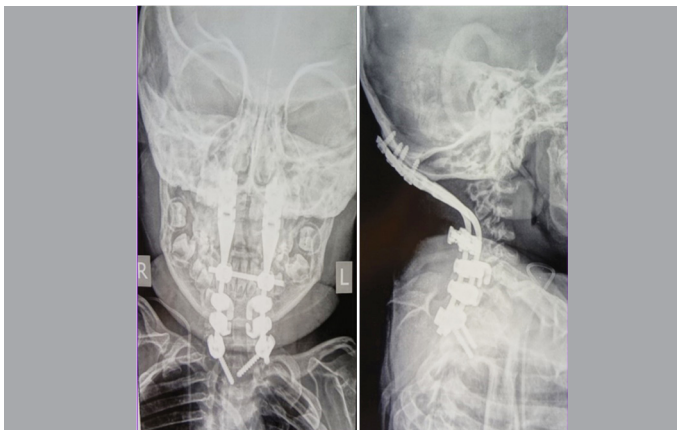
Postop X-rays. The position of the implants. First sibling.
